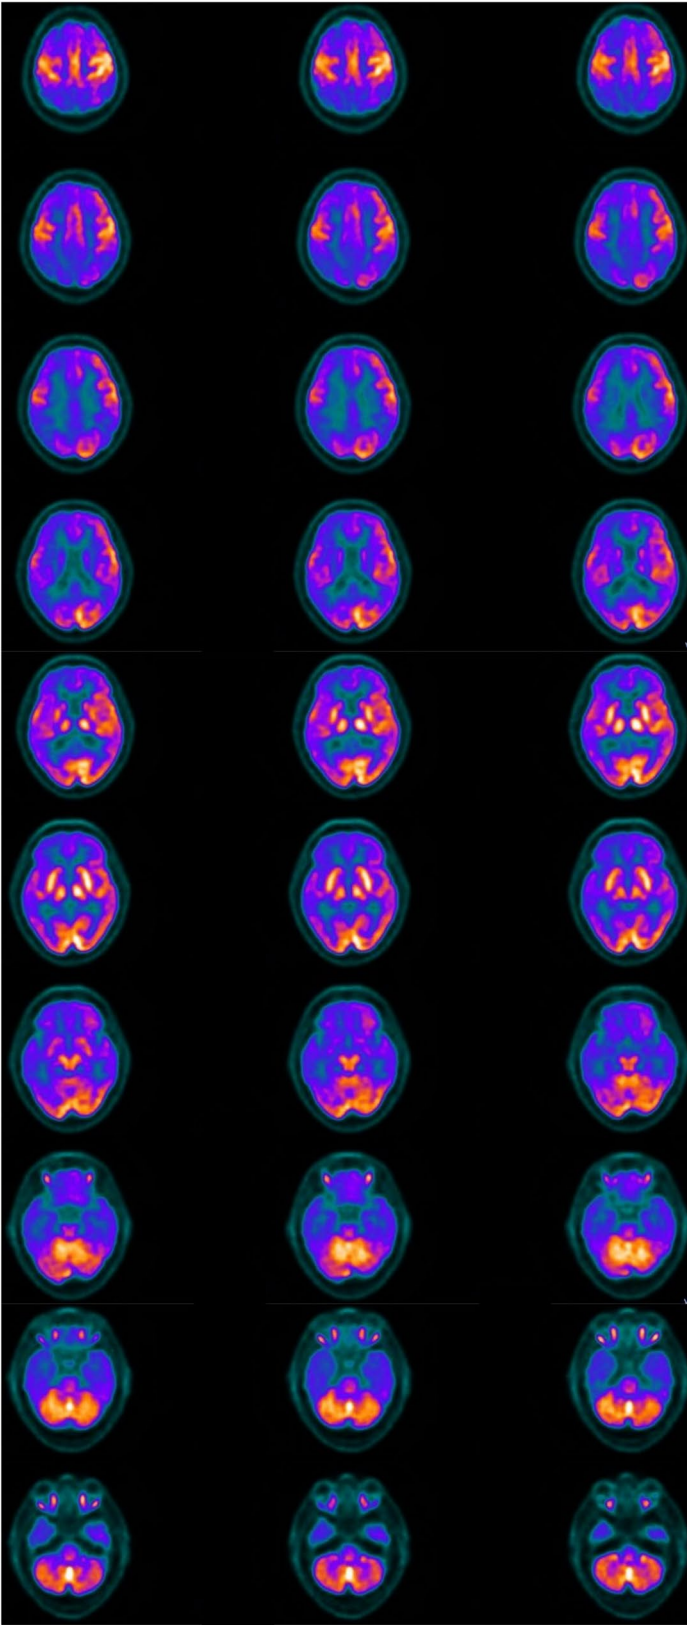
FDG-PET scan showing hypometabolism in the prefrontal areas, parieto-temporal cortex, posterior cingulum, and precuneus bilaterally, as well as in the left fronto-mesial area and anterior cingulum
